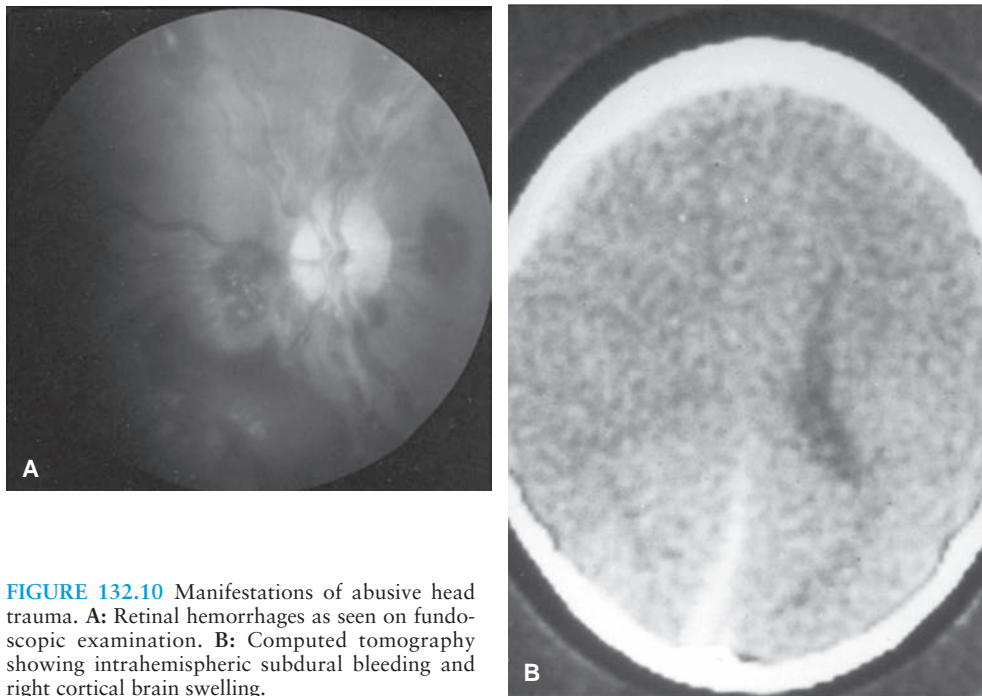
Manifestations of abusive head trauma. A: Retinal hemorrhages as seen on fundoscopic examination. B: Computed tomography showing intrahemispheric subdural bleeding and right cortical brain swelling.
